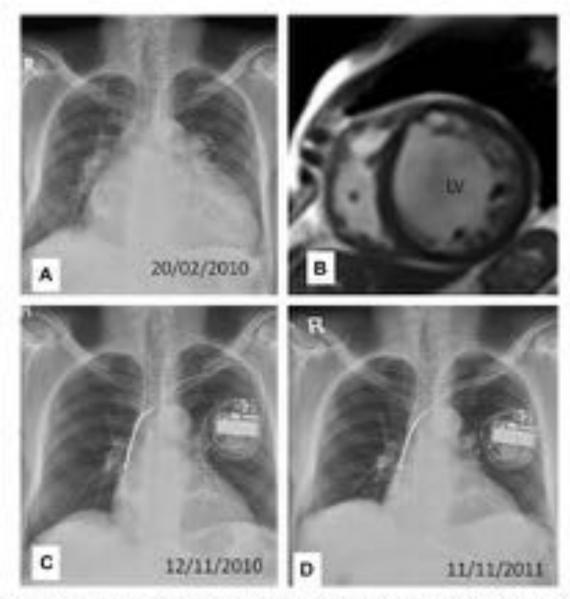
A  $\phi$  8 - Biseline closel X-ray and ME image; C  $\phi$  D - Sorial follow up closel X-ray images.
